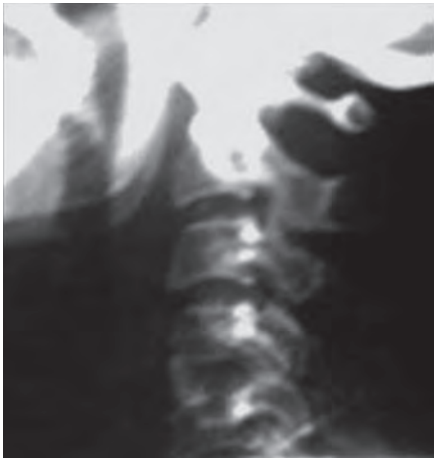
X-ray on 1st post-operative day of patient (Fig. 2A) who had underwent ACDF
